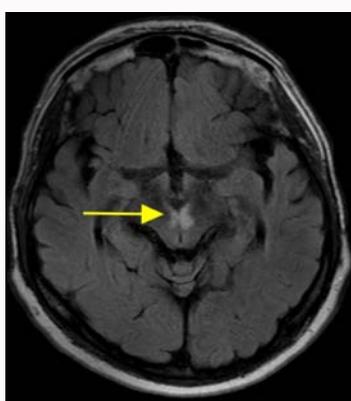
Axial FLAIR sequence shows hyperintensity in the paramedian thalamus and central midbrain (yellow arrow).
